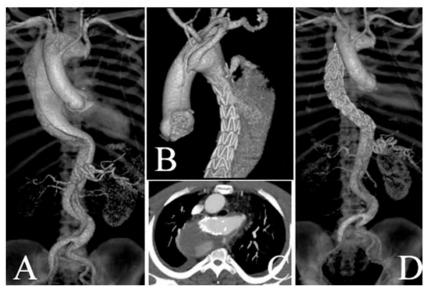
65 years old patient with right sided aortic arch with aneurysmal dilatation of descending thoracic aorta and Stanford type B dissection. (A-D) pre and post EVAR CTA images. A,B&D VR images,C axial 2D image revealed pre EVAR Stanford B dissection (A), Type Ia endoleak 3 month after EVAR (B&C) and follow after 11 month revealed resolution of endoleak (D).
